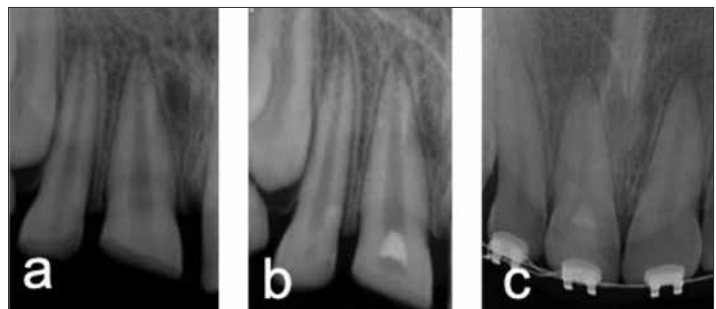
Radiographic appearance of case 3; a – preoperative; b – postoperative; c – postoperative six years follow-up
